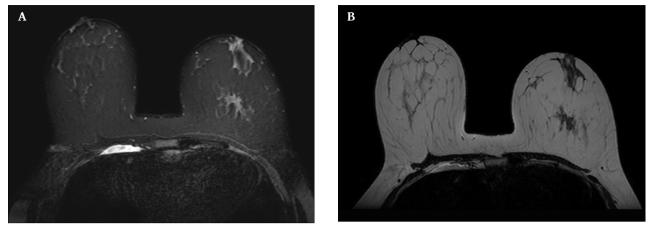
A. Sclerosing adenosis of the left breast in a 40-year-old woman. Axial T1-weighted image displays a centrally located low signal intensity stellate lesion in the posterior aspect of the left breast. B. The corresponding STIR image shows increased signal intensity of the stellate lesion in the posterior aspect of the left breast.
